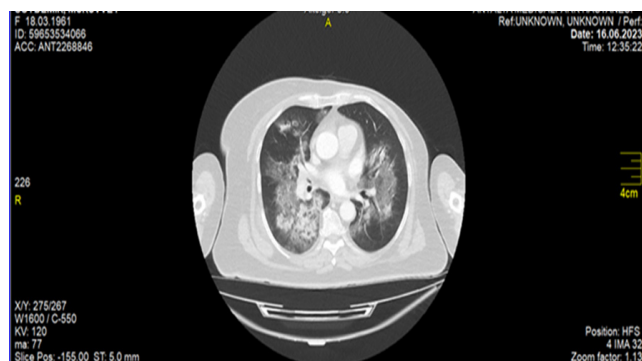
Thorax computed tomography with bilateral alveolar hemorrhage
